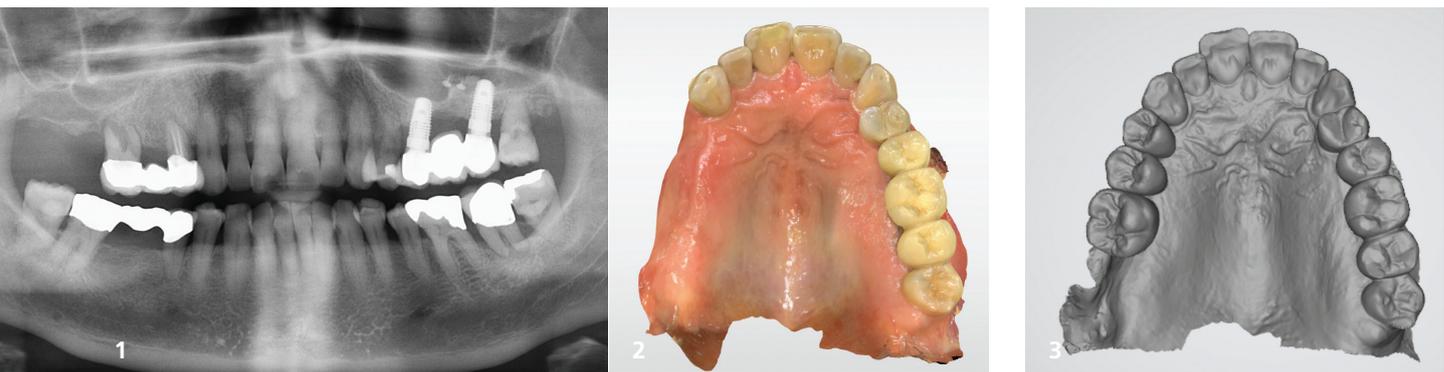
Preoperative radiograph prior to placement of two ceramic implants. Fig. 2: Intra-oral scan for implant planning (CEREC Primescan, Dentsply Sirona). Fig. 3: STL data set with prosthetic proposal.
